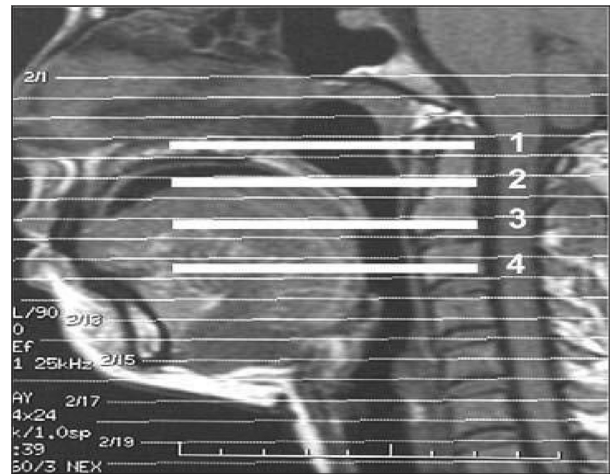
Magnetic resonance imaging sagittal section showing 1: Rhinopharynx (not measured), 2: High retropalatal oropharynx, 3: Low retropalatal oropharynx, retropalatal oropharynx (minimum) – measured between 2 and 3, 4: Retroglossal oropharynx (minimum)
